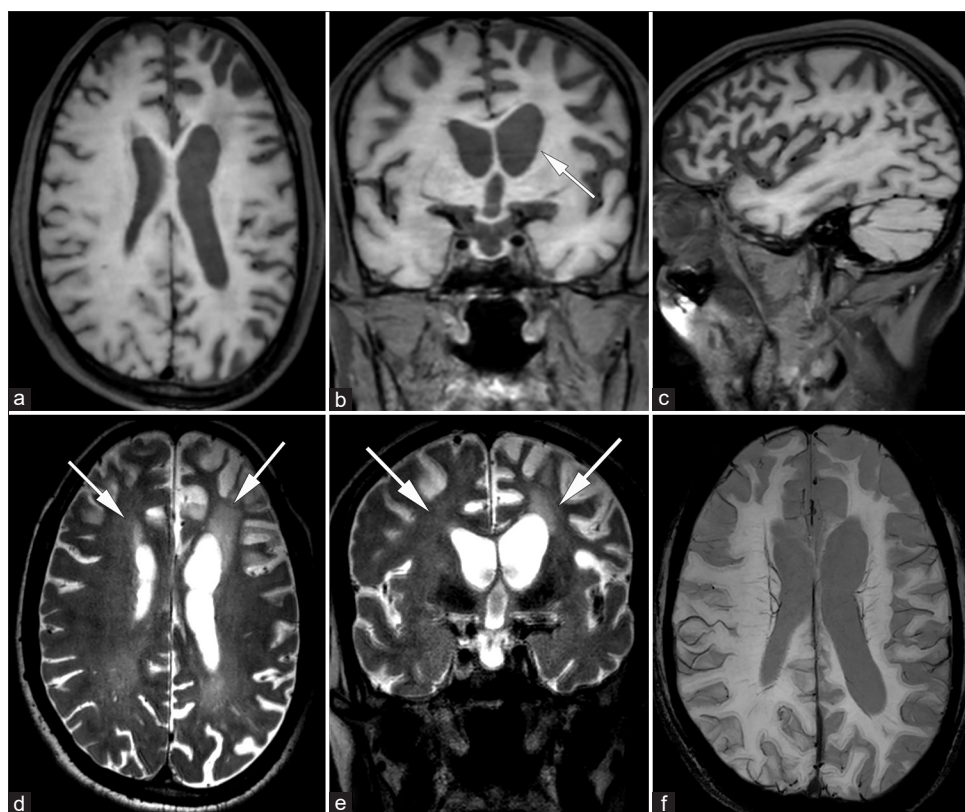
Axial (a), coronal (b), and sagittal (c) T1-weighted images show asymmetrical cortical atrophy in bilateral frontal lobes, parietal lobes (L > R), and the left caudate head (arrow in b). The frontal atrophy is more on the left side with an anterior-to-posterior gradient (c). The bodies of the left lateral ventricle and left frontal horn are dilated. Axial (d) and coronal (e) T2-weighted images show hyperintensity in both frontal white matter (L >> R) (arrows in d and e). Axial susceptibility-weighted image (f) shows no evidence of iron deposition or hemorrhage
